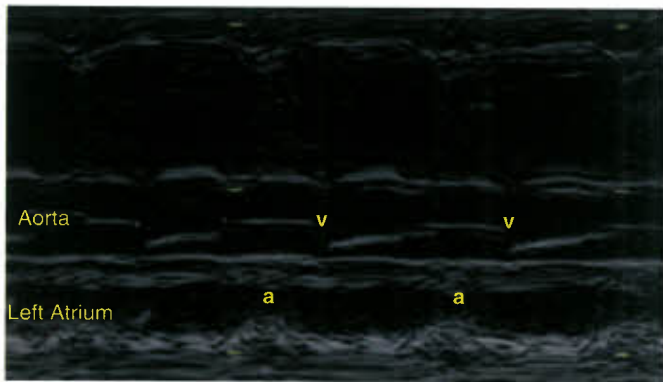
M-mode echocardiographic tracing recorded through aortic root of fetus with atrial ectopic tachycardia at 180 beats per minute. The aortic valve opening (v) corresponds to the mechanical response to electrical stimulation leading to ventricular myocardial contraction. Note that there is one atrial undulation (a) for each ventricular contraction.
